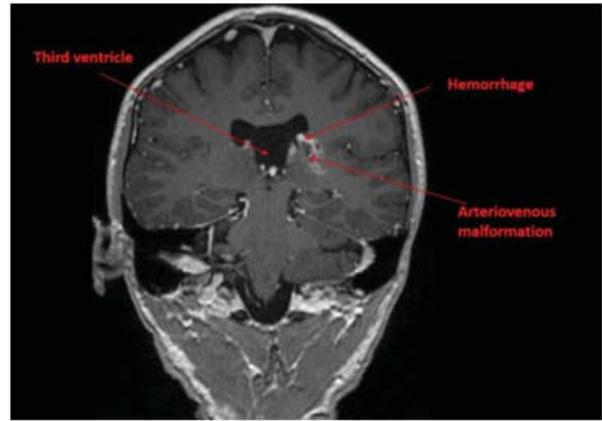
Magnetic resonance image of the brain showing intracranial haemorrhage in the left basal ganglia with intraventricular extension. Small arteriovenous malformation arising in the thalamus is also visualised.
